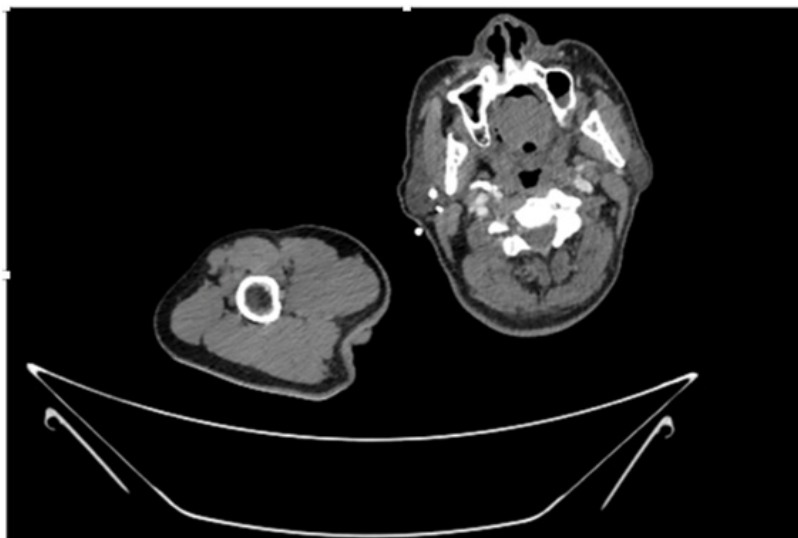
CT Angiogram at upper arm showing totally occluded right axillary artery.
